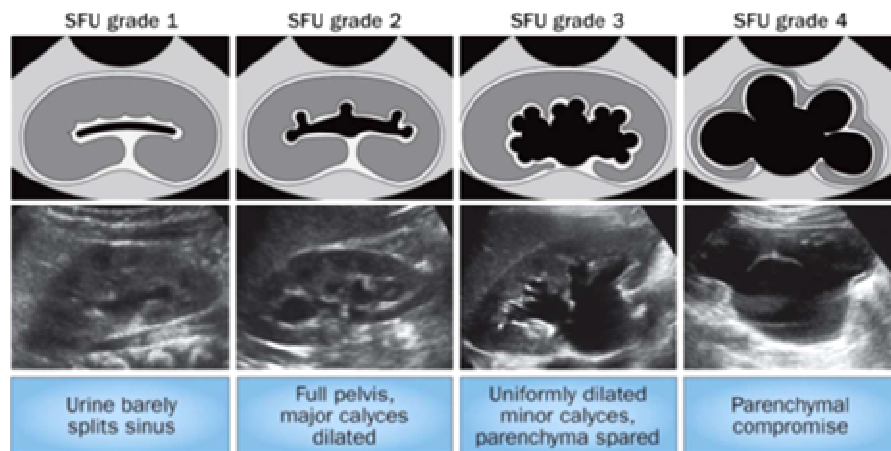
Ultrasound pictures of the various grades of hydronephrosis by SFU⁽¹¹⁾.
